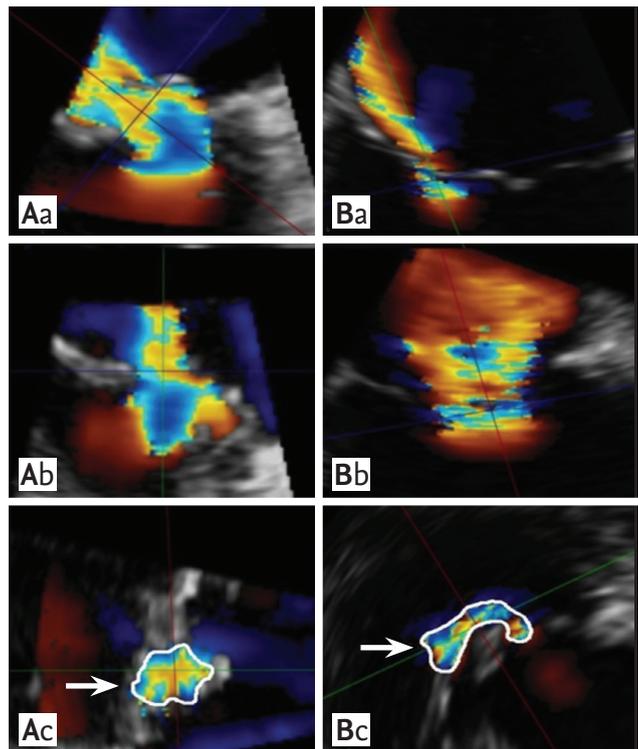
Difference in the shape of vena contracta from degenerative mitral valve disease (Ac) and functional mitral valve disease (Bc) delineated by color Doppler 3-dimensional transesophageal echocardiography.
